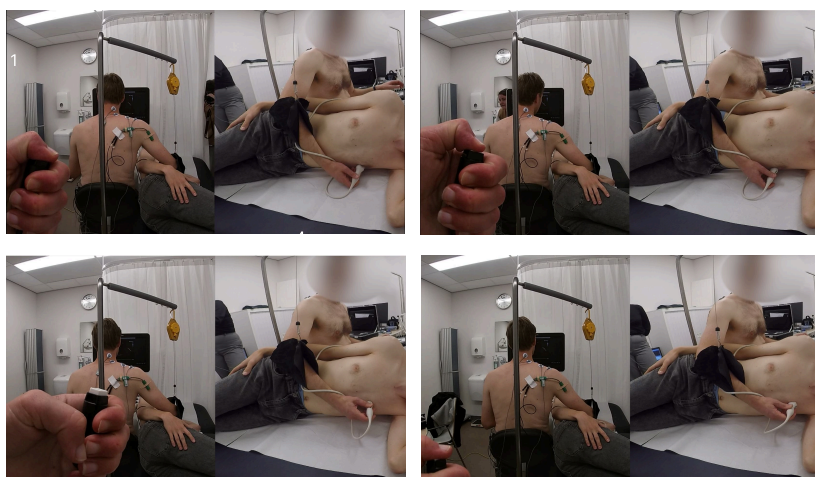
Four postures during the ultrasound
